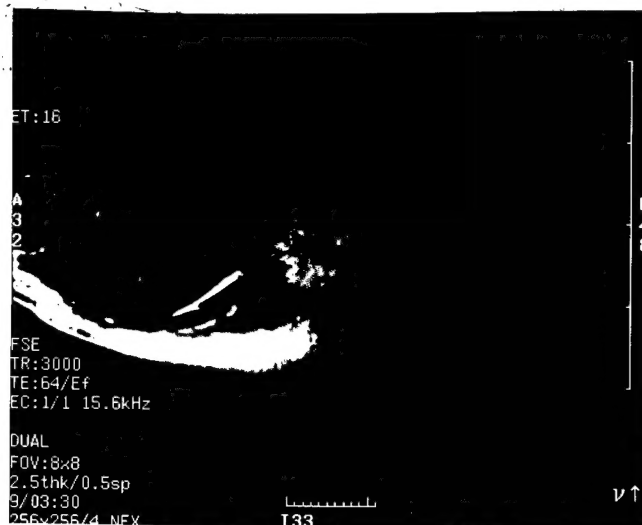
High resolution T1-weighted image obtained from an invasive ductal carcinoma. (a) Pre-contrast T1-weighted image acquisition parameters were: TR=300ms; TE=11ms; FOV=8cm x 8cm; 256x256 matrix; slice thickness = 2.5 mm, number of averages = 3. (b) T2-weighted image acquisition parameters were as above except TR=3,000 ms; TE=64ms.
